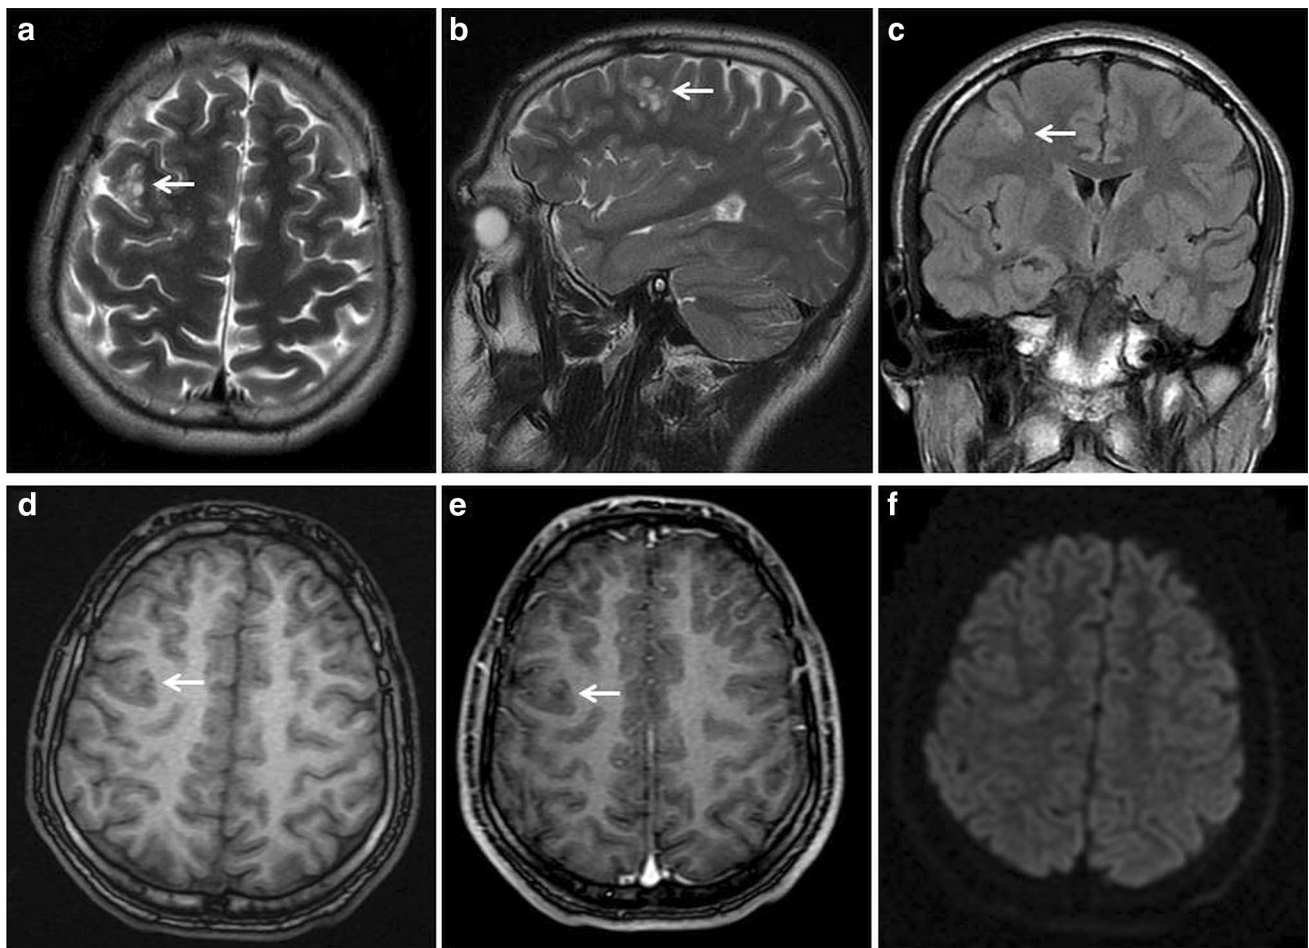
Brain MRI of a 21-year-old male patient with epilepsy. a Axial, b Sagittal T2 weighted images of multinodular hyperintense lesion in cortical–subcortical area in right middle frontal gyrus. c Heterogeneous hyperintense appearance of the lesion on FLAIR
